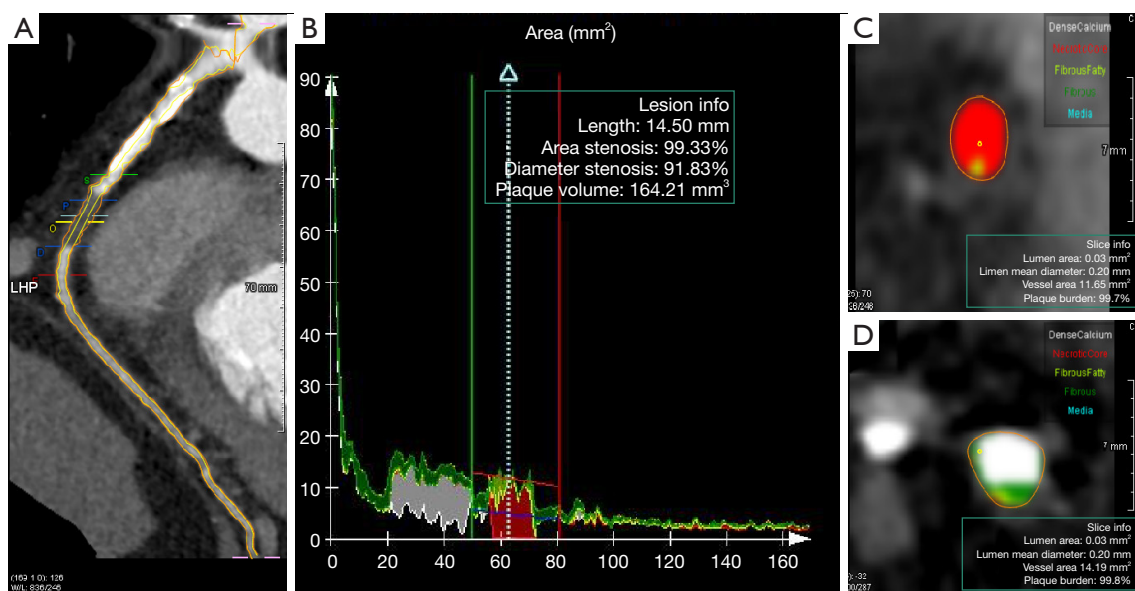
Example of quantitative CCTA analysis of an RCA CTO lesion. (A) Multiplanar reconstruction of an RCA vessel. “P (in blue)” is the proximal and “D (in blue)” is the distal section of the chronic total occlusion. “S (in green)” is the proximal normal reference section, and “E (in red)” is the distal normal reference section. (B) Lumen and vessel area line chart graph according to distance from the ostium of the target vessel. (C) Transverse section composed of necrotic core tissue (red area). (D) Transverse vessel section mainly composed of fibrous tissue (green area) and calcification (white area). CCTA, coronary computed tomography angiography; RCA, right coronary artery; CTO, chronic total occlusion.
